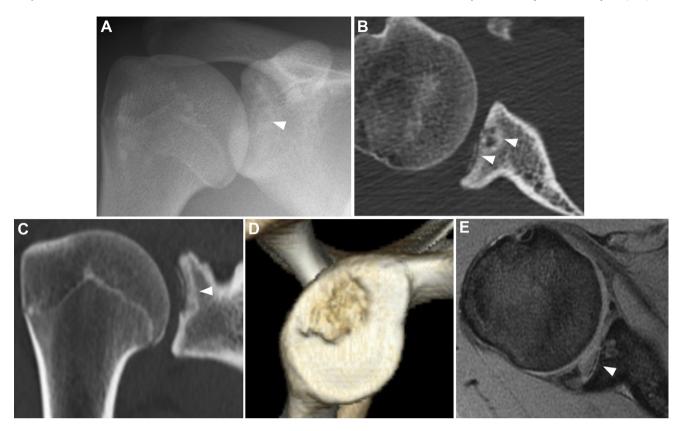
Anteroposterior radiograph of the right shoulder showed an osteosclerotic change (*arrowhead*) in the glenoid (A). Computed tomography (B, C, D) showed a fragment and sclerotic change (*arrowheads*) in the glenoid. Axial T2-weighted magnetic resonance imaging (E) demonstrated a high linear signal (*arrowhead*) at the subchondral bone of the glenoid.
